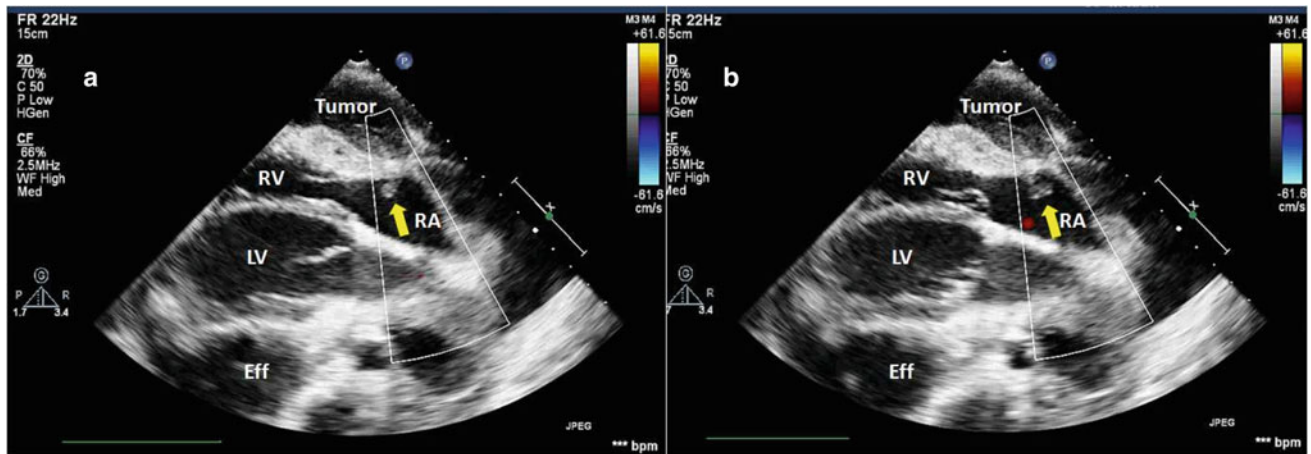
A. Diastolic frame from echocardiogram parasternal long axis view demonstrating mass ingrowth (arrow) to the right ventricle. B. Systolic frame. The left ventricle appears mildly hypokinetic. Eff—pleural effusion, LV—left ventricle, RA—right atrium, RV—right ventricle
